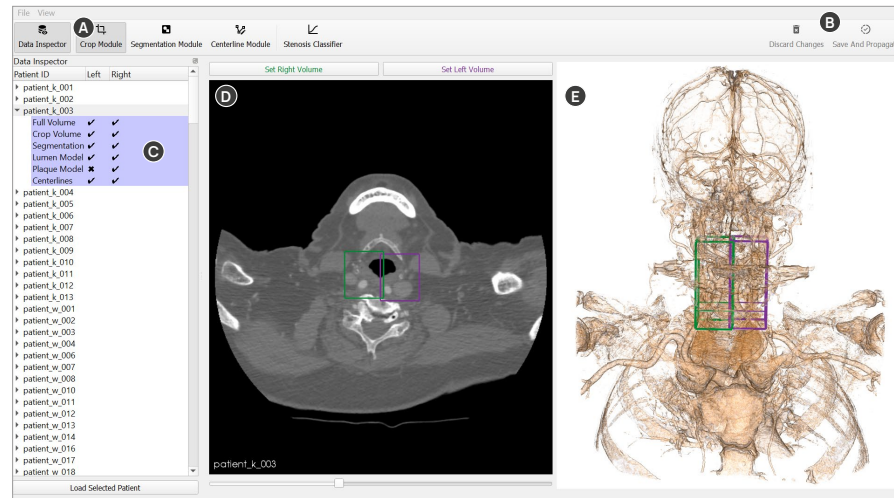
User interface of the analysis framework. (A) Module selection bar. The crop module is currently active. (B) Global discard and save buttons. (C) The data inspector shows the list of available data sets and which files exist for the left and right carotid. (D) Slice view of the crop module. The left and right volumes can be set here. (E) Volume rendering of the CTA scan with the selected crop regions highlighted.
